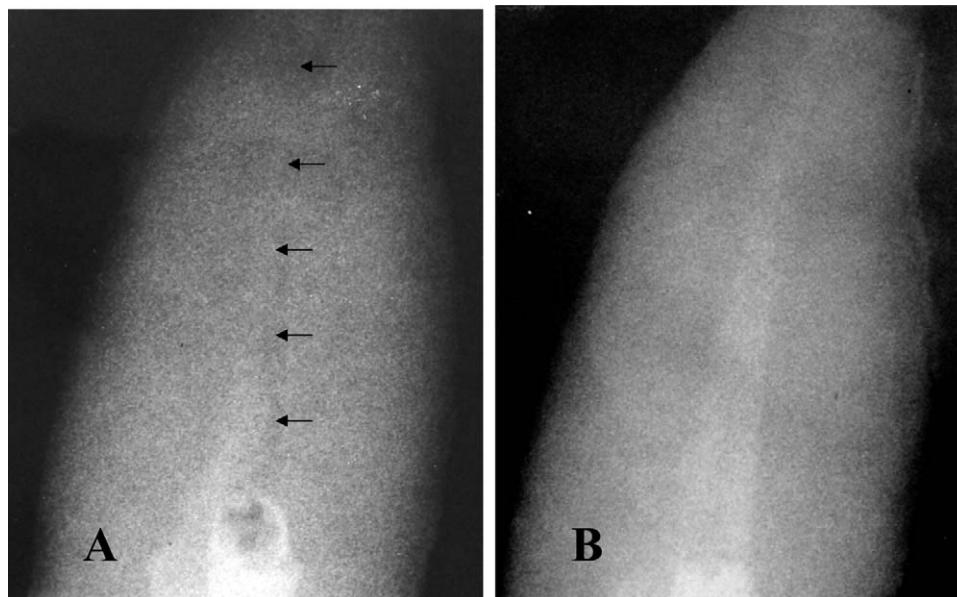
Radiographic examples of minimally (A) and completely prepared (B) canals filled with $\text{Ca}(\text{OH})_2$. Note large areas of unfilled canal (arrows) in the minimally prepared canal.
